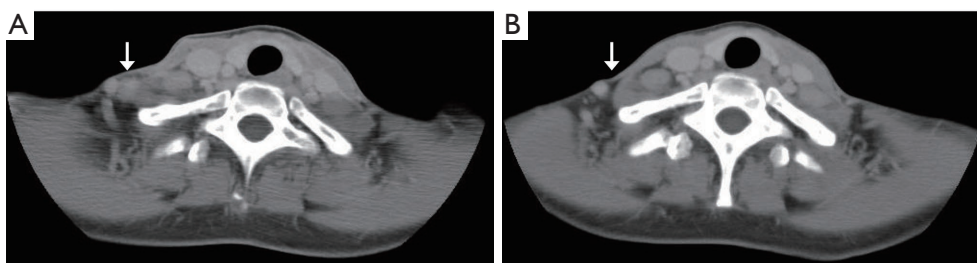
Cervical CT before and after initiating gefitinib. (A) Before initiating gefitinib, post-operative recurrence in the right supraclavicular nodes (shown by arrow) was observed. (B) After initiating gefitinib, the right supraclavicular nodes extremely shrank (shown by arrow). CT, computed tomography.
